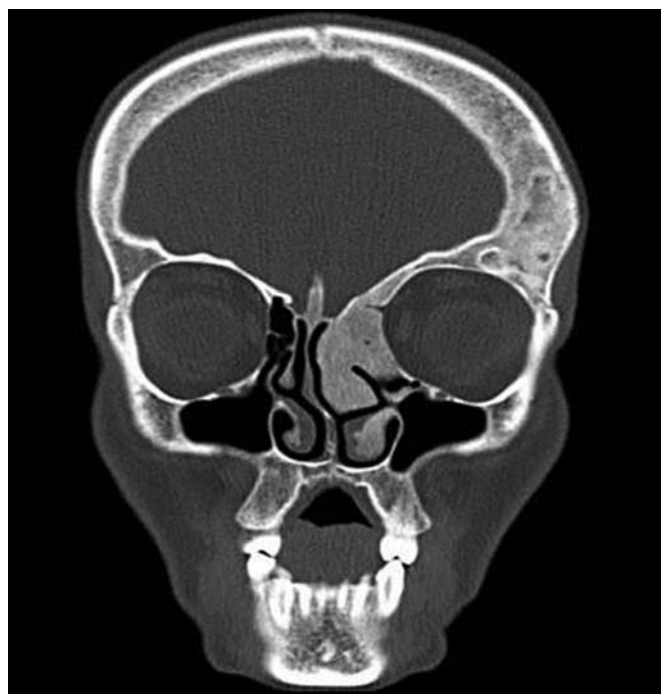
Coronal CT showing fibrous dysplasia in the left nasal cavity.
